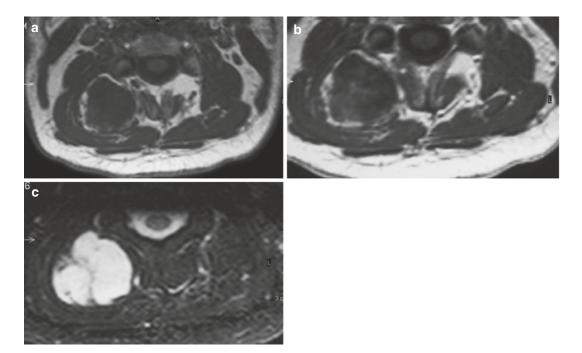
(a–c) Nuchal fibroma. (a) Axial spin-echo T1-weighted MR image. (b) Axial spin-echo T1-weighted MR image after gadolinium contrast injection. (c) Axial short-tau inversion recovery (STIR) MR image. Atypical
